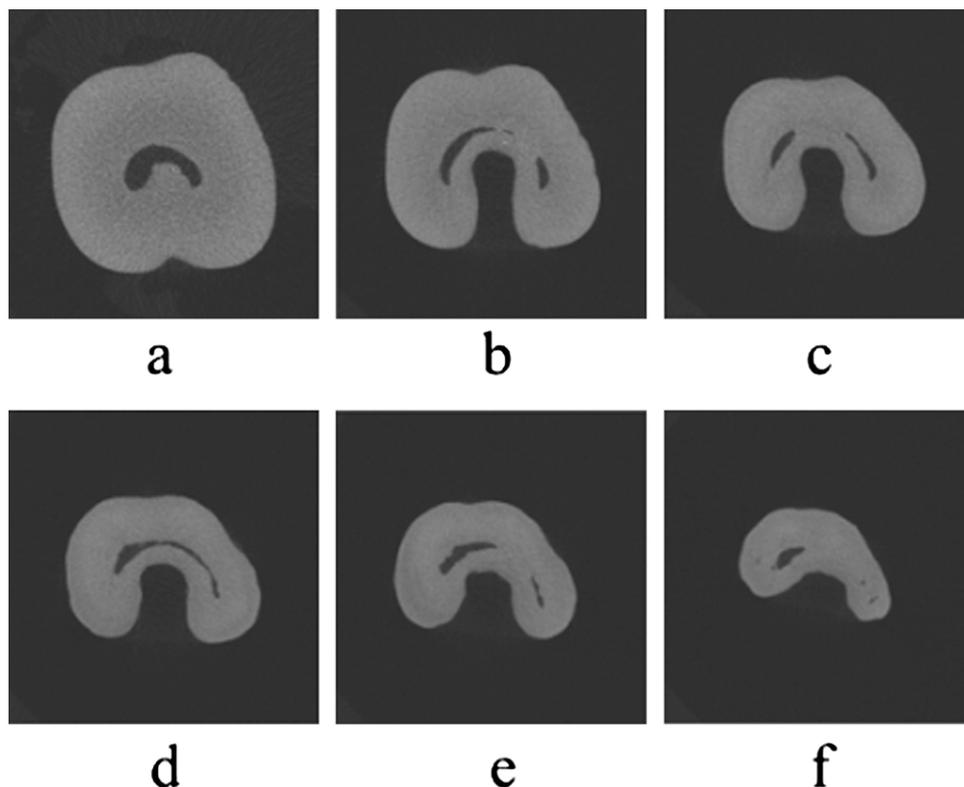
Examples of some μ CT images of a tooth with C-shaped canal system. (a) Canal orifice; (b) coronal—third point; (c) mid-root; (d) apical—third point; (e) 2 mm above apex; (f) 1 mm above apex.
